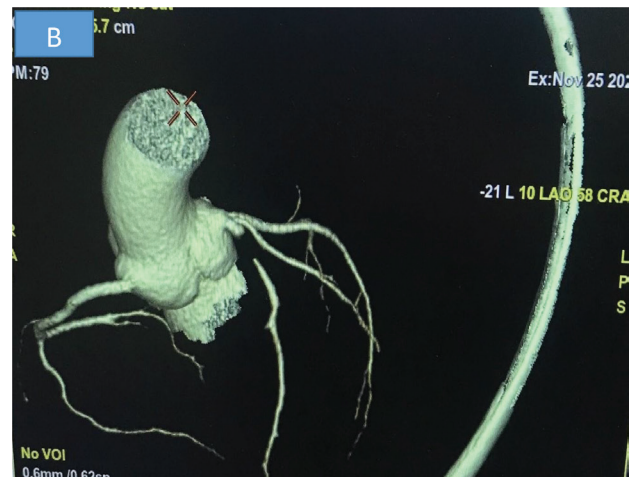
B: 3D image of Coronary computed tomography angiography showing contrast filling defect in proximal Left anterior descending artery
